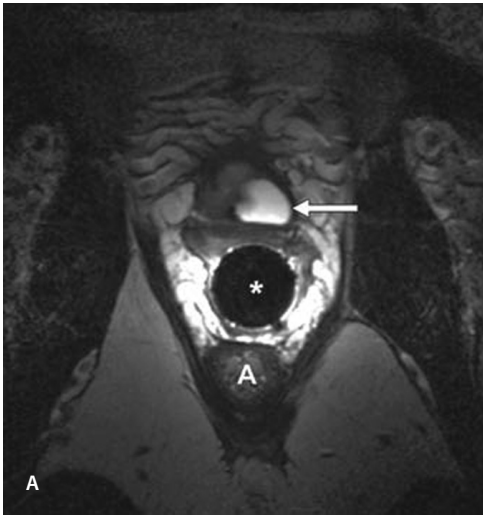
35-year-old-woman with urethral diverticulum. A, Axial T2-weighted image shows endoluminal coil (asterisk) placed in vagina. Arrow indicates locally rounded urethral diverticulum on left, A indicates anus. B, On next lower slice image, ostium of urethral diverticulum can be seen posteriorly as linear extension of diverticular neck through layered structure of urethra in midline (arrow). Arrowheads show puborectal muscles with thinning and fibrosis of left compared with normal muscle thickness on right side. Asterisk indicates endoluminal coil, A indicates anus. C, Sagittal T2-weighted image shows diverticulum consisting of two parts (straight arrows) and facilitates precise measurement of distance of diverticular neck (curved arrow) to bladder base. Asterisk indicates endoluminal coil placed in vagina, B = bladder, S = pubic symphysis, A = anus.
